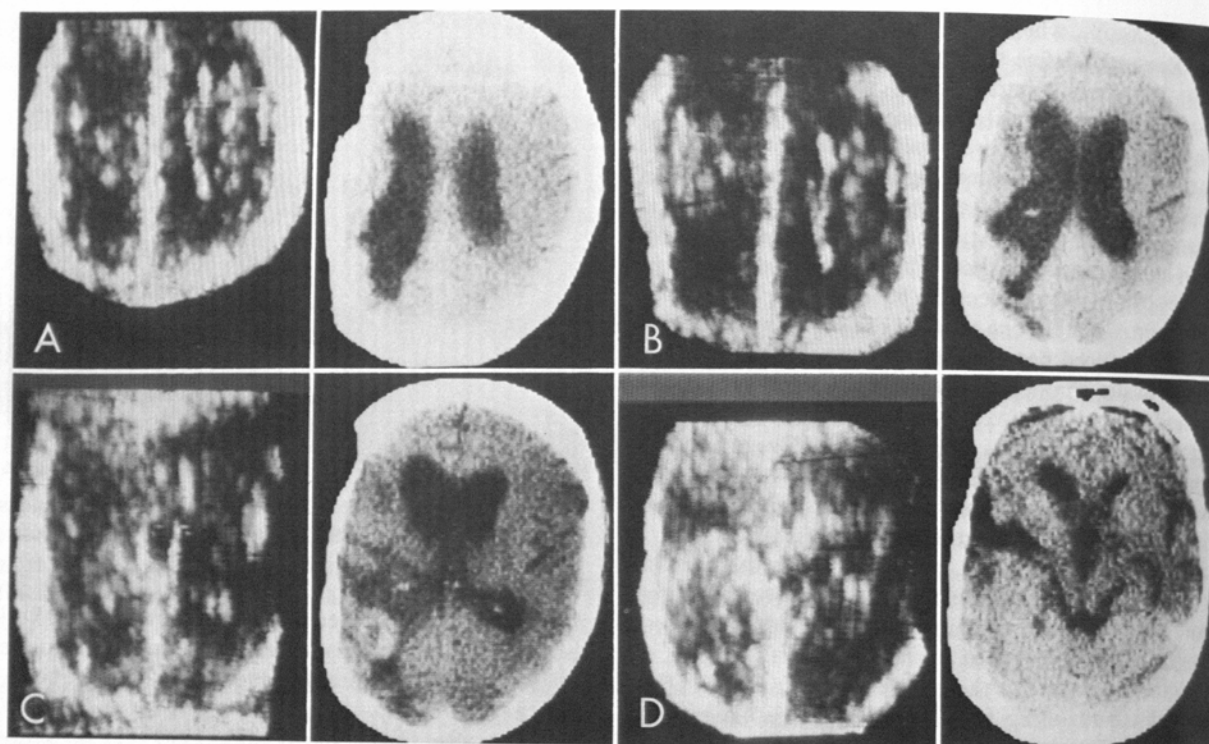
Series of corresponding horizontal brain scans obtained via the UTIS (left) and contrast enhanced x-ray CT (right). Orientation is the same as in Fig. 4. Scans run in 1-cm successive increments from most cranial (A) to most caudal (D), ie, most cranial (A) and caudal 1 cm (B), 2 cm (C), and 3 cm (D) from position of (A). The tumor (glioblastoma multiforme) is clearly seen in (C) and (D) using both visualization techniques.
